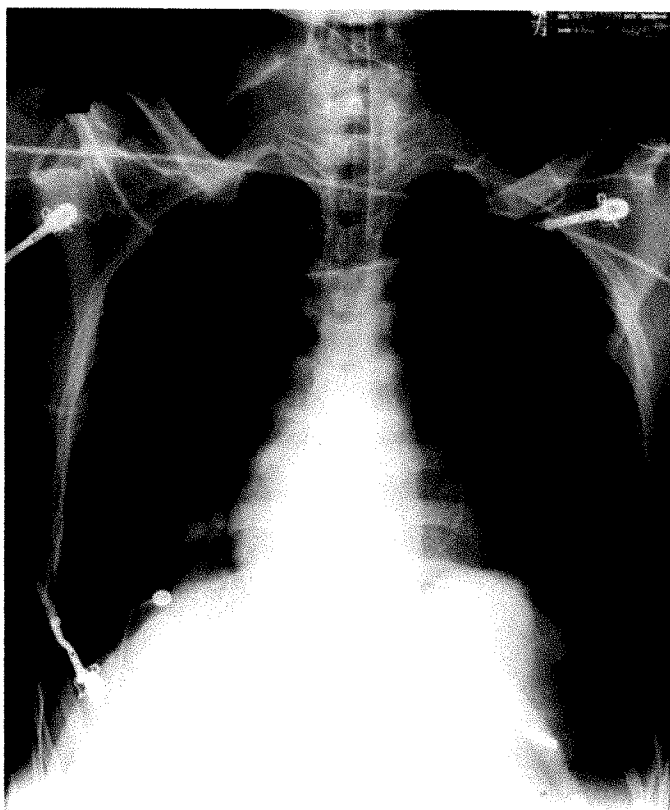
A chest radiograph taken 8 hours after surgery.
